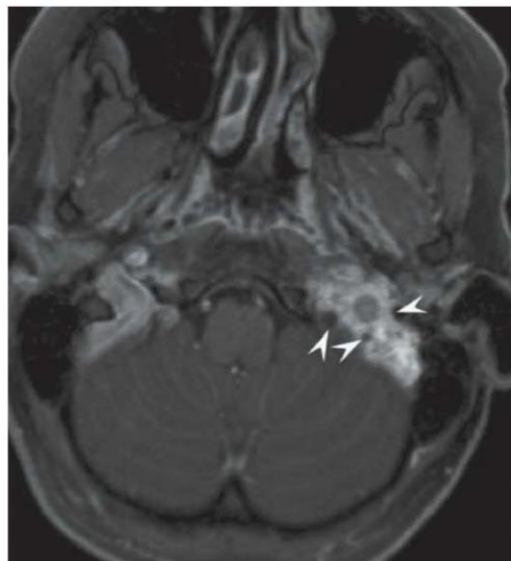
Axial T1-weighted contrast-enhanced MRI image at the level of the left jugular foramen demonstrating an enhancing glomus jugulare tumor with dark intratumoral flow voids (*arrowheads*).
